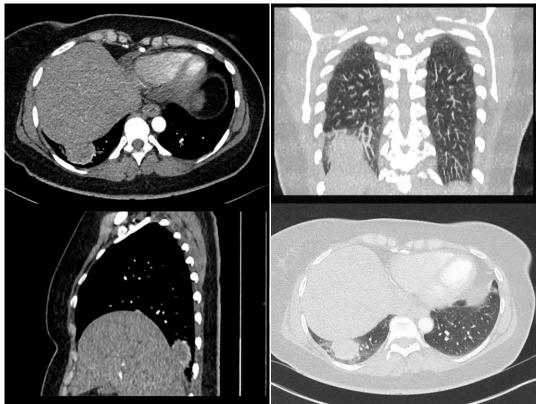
Axial, Coronal and Saggital reconstructions of CT Abdomen and Thorax
